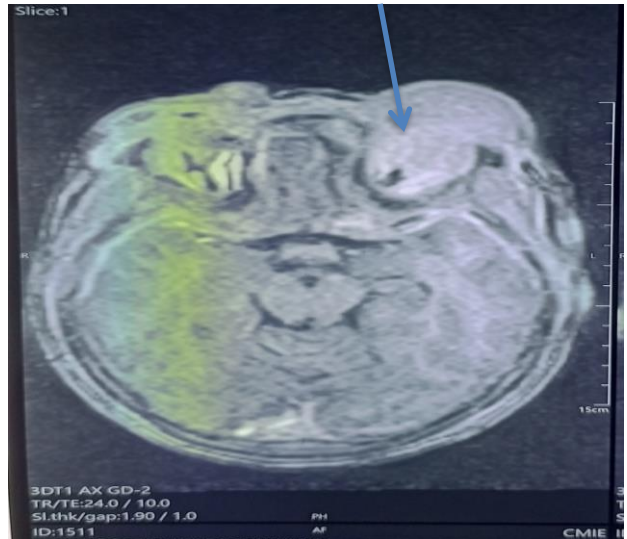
Orbital MRI which shows a tumor process enhanced in the eyelid orbital regions.
